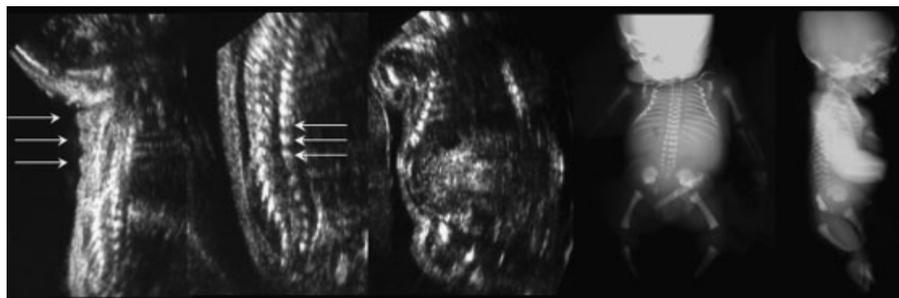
Ultrasound scan and postnatal radiographs of fetus 1. Note redundant skin (arrows on the left), platyspondily (arrows on the right), bell-shaped thorax, wide femoral and humeral metaphyses.
